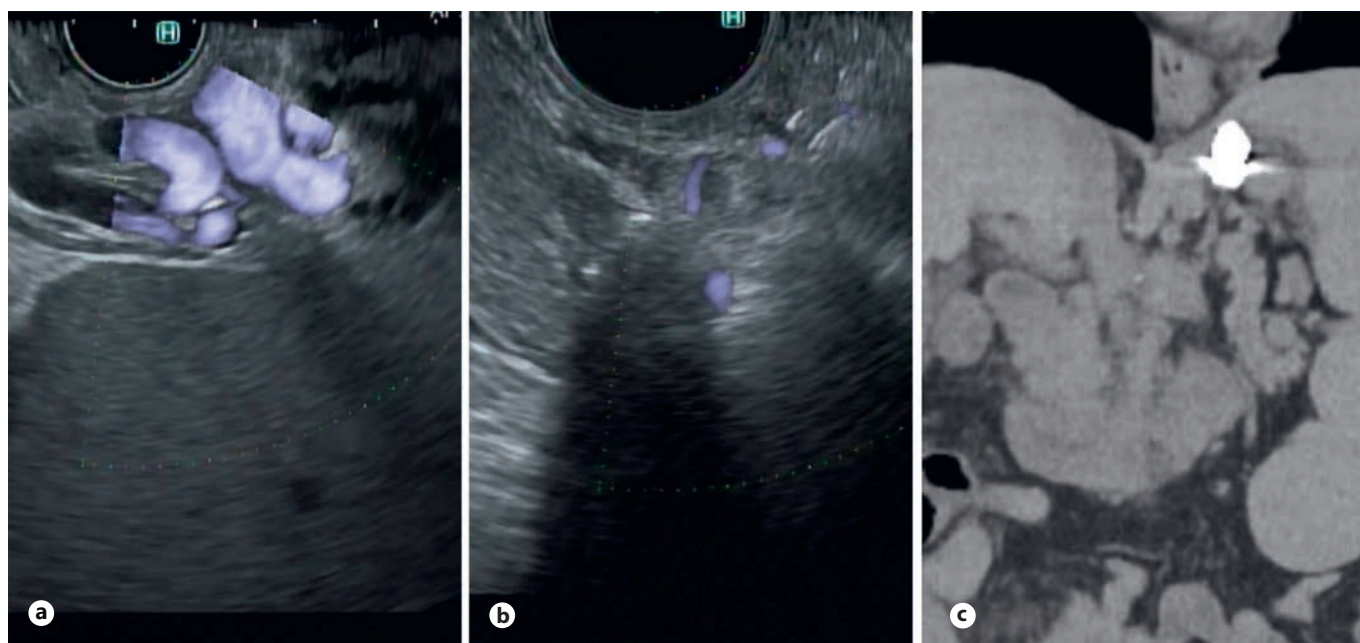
EUS-guided variceal embolization. a Gastric varices as seen by linear echoendoscopy. b Echo image after placement of coils and glue into gastric varix via a 19G needle. Lack of flow as seen by Doppler. c Follow-up coronal CT scan obtained for routine management showing coils in place within the gastric varices.
